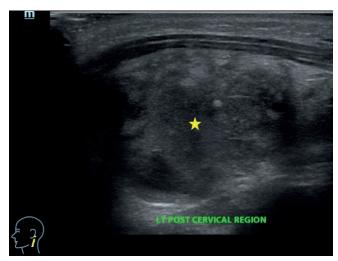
Ultrasound scan of the neck shows a well-defined heterogeneous hypoechoic collection at the left posterior triangle, measuring 2.3 cm x 3.6 cm x 3.9 cm (centre of collection marked with yellow star).
